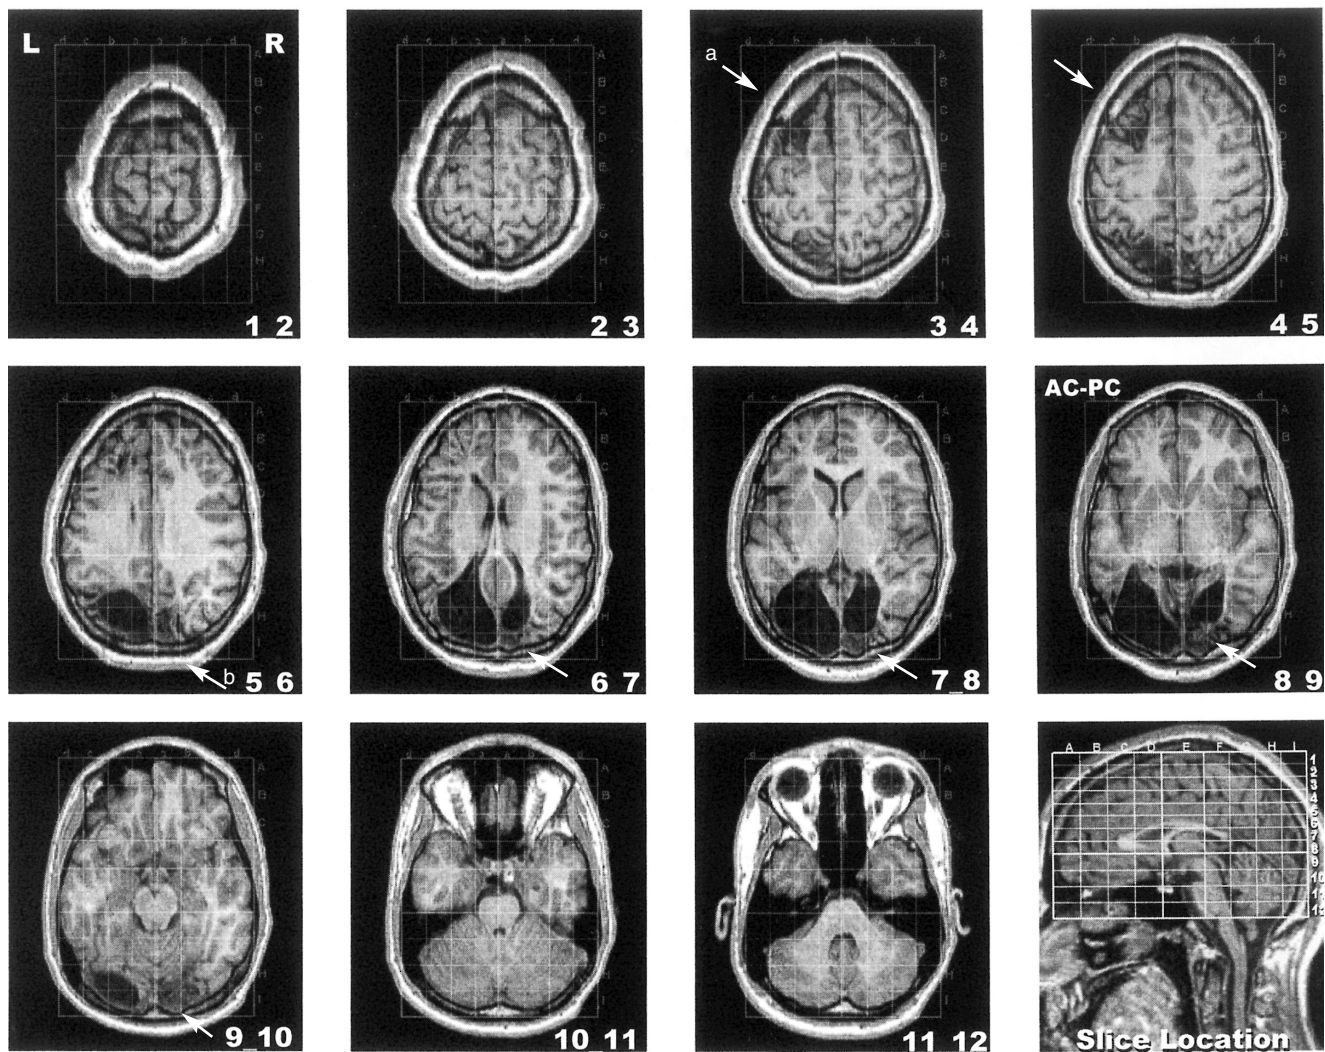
Anatomic MRI images showing extent of patient's lesions. There is (b) extensive gliosis in right occipital horn. Also note (a) smaller infarct involving left frontal lobe. Slice number in each frame corresponds to horizontal section defined in stereotaxic atlas of Talairach and Tournoux (1988).
